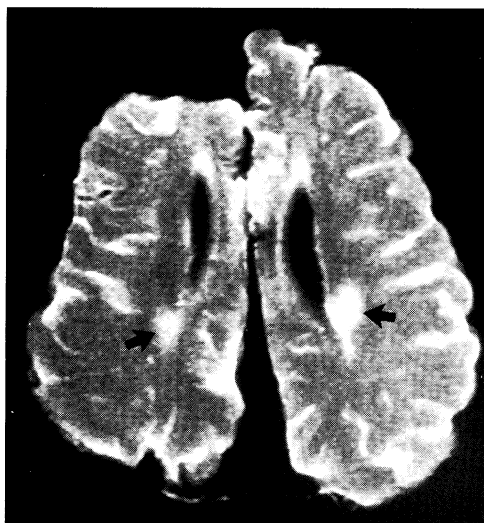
Case 2. Postmortem (fixed brain) axial MR T2-weighted image (3000/90/1) shows abnormal areas of high signal intensity (arrows) in periventricular white matter.
